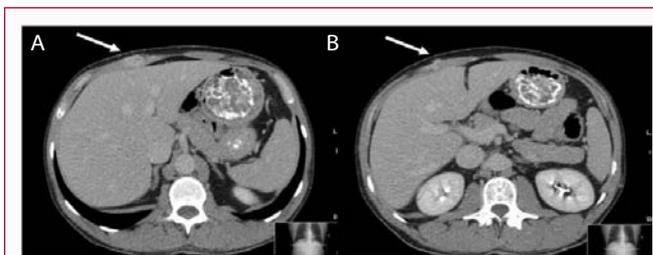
A) The pre-operative CT scan showing a right rectus abdominis muscle at the level of epigastrium a captant nodular lesion; B) another lesion just inferior to the latter one with the same characteristics.
